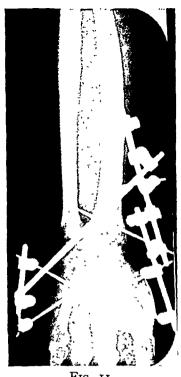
Case 11: Roentgenographic appearance of an arthrodesis of the wrist joint using an osteoperiosteal graft 12 weeks postoperatively. The indication for surgery was a posttraumatic arthritis of the radiocarpal joint following old ununited fracture of the carpal scaphoid. The position of the 3/2-pins are shown in the roentgenogram; three half-pins in the radius, one half-pin unit in the second metacarpal shaft and one half-pin unit in the fifth metacarpal shaft. Radialulnar movement is preserved during the healing period. Bony ankylosis is present.
